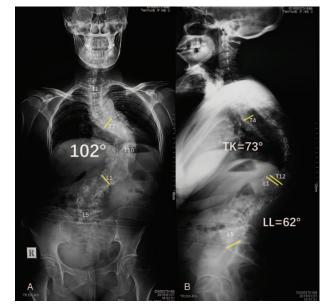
Upright radiographs of the whole spine of the proband's mother. (A) Anteroposterior radiograph showing a Cobb angle of 102° at T7-L1. (B) Sagittal radiograph showing thoracic kyphosis (TK) of 73° and a lumbar lordosis (LL) of 62°.
